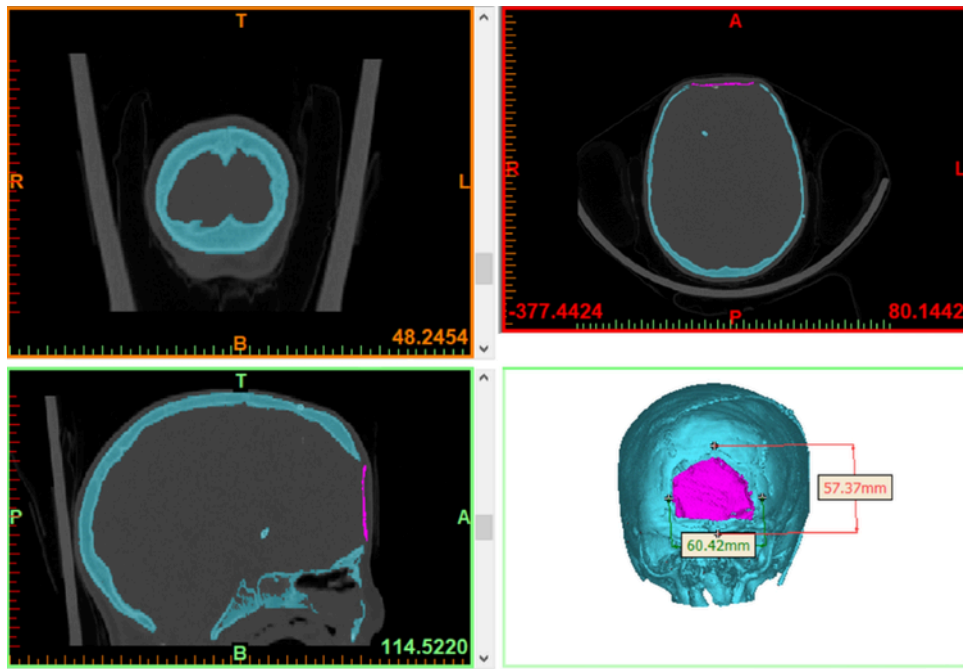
CT scan obtained for the exemplificative case study used to describe the proposed procedure. Since the CT scan data are segmented, the plate to be removed is colored in pink while the segmented bone before surgery is colored in cyan. (For interpretation of the references to colour in this figure legend, the reader is referred to the web version of this article.)
